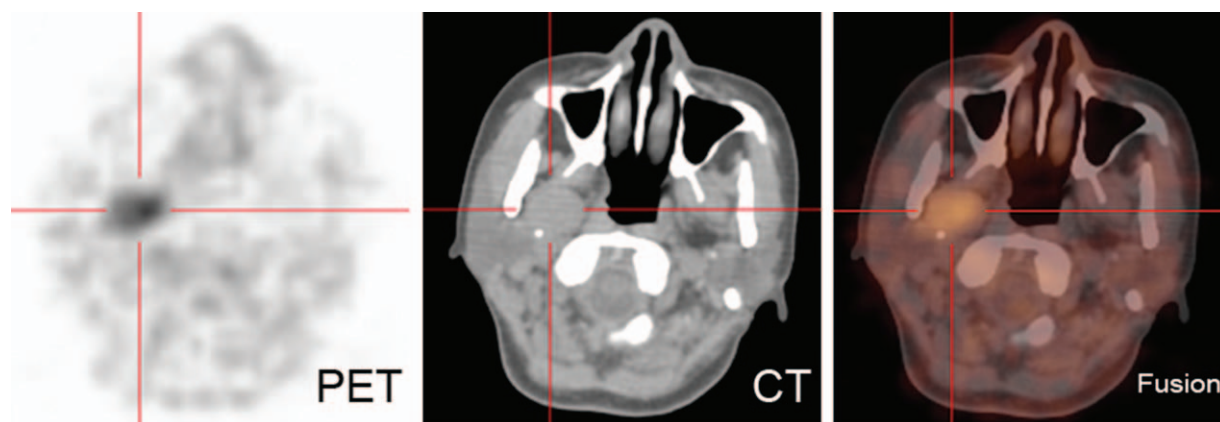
Positron emission tomography (PET) images revealed increased uptake of ^{18}F -deoxyglucose in the right parapharyngeal space, corresponding well to the mass shape on computed tomography (CT) and the fusion images.
